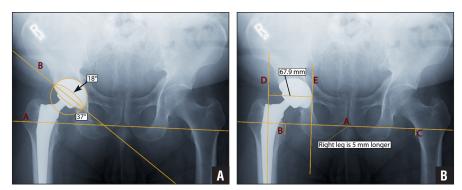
Supine anteroposterior pelvis radiograph showing measurements for cup anteversion and inclination angles. Line B is the tangent line to the opening of the acetabular cup and intersects with the interobturator reference line A on the pelvis, giving the inclination angle (37°). The ellipse that measures the anteversion angle (18°) is delineated by the contour of the acetabular cup opening and is concentric with the circle surrounding the acetabular cup (A). Supine anteroposterior pelvis radiograph showing measurements for leg-length discrepancy and global offset. Line A is the reference on the pelvis. Leglength discrepancy of 5 mm is the difference between lines B and C. Line D delineates the anatomic axis of the femur, and line E is parallel to the anatomic axis, tangent to the teardrop (or to the most medial aspect of the acetabular cup when the cup is more medial than the teardrop). The perpendicular distance between lines D and E passing through the center of the femoral head gives the global offset value of 67.9 mm (B).
